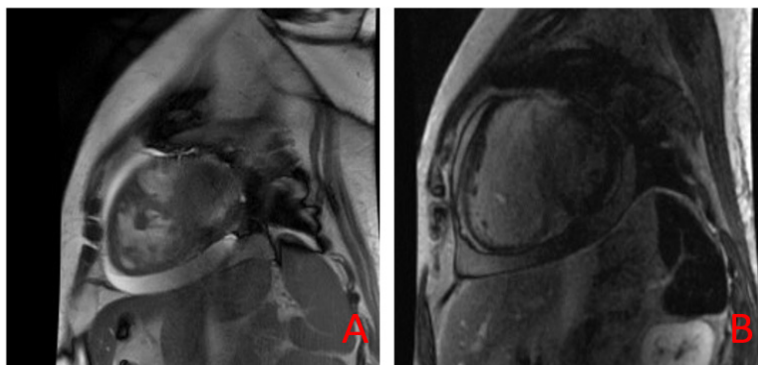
Cardiac MRI findings in the proband: (A) Cardiac cine sequence reveals features consistent with non-compaction cardiomyopathy; (B) Gadolinium-enhanced sequence shows right atrial and right ventricular dilation, an increased number of moderator bands in the right ventricle, and patchy fibrosis in the right atrium.
